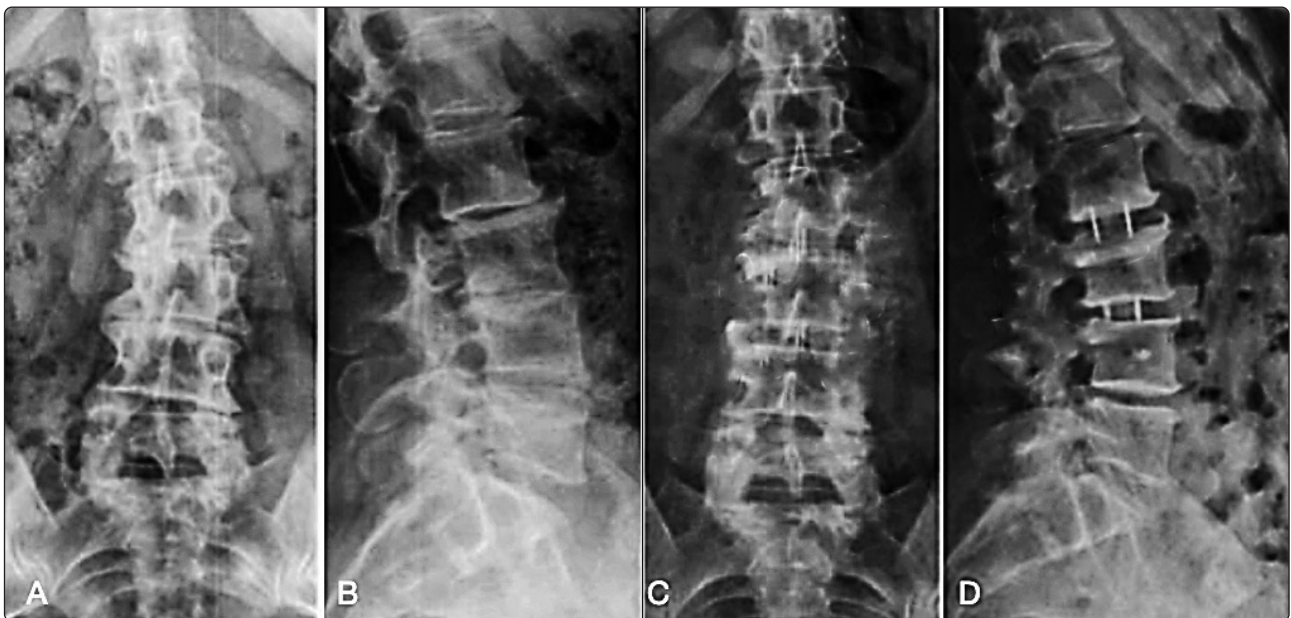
A 31-old-male patient with degenerative scoliosis L2/L3 and L3/L4 complaining of back pain and leg pain for 12 months. (A) AP X-ray L/S spine denoting degenerative scoliosis Cobb's angle of 24 degrees; (B) Lat. X-ray L/S spine with decreased disc spaces and straightening of the lumbar spine, SVA: 10 mm, PT: 16 degrees, SS: 42 degrees, LL: 24 degrees, PI/LL mismatch: 27, and anterior disc height: 7.2 mm for L2/L3 and 8.3 mm for L3/L4; (C) AP L/S spine after OLIF levels L2/L3/L4 1-year follow-up shows improved Cobb's angle to 9 degrees, and (D) lateral X-ray L/S spine 1-year follow-up shows increased anterior disc heights 11.5 mm for L2/L3, 12 mm for L3/L4 on L2/L3 and L3/L4, SVA: 8 mm, SS: 43 degrees, PT: 14 degrees, LL: 35 degrees, and PI/LL: mismatch: 18.
